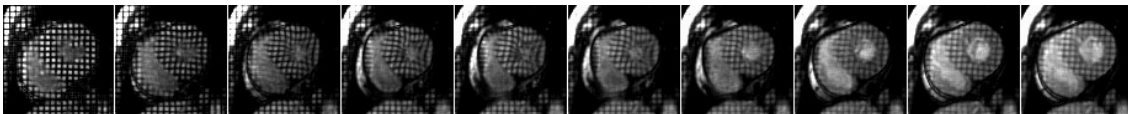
Tagged MR images of a short-axis slice of a patient's heart
